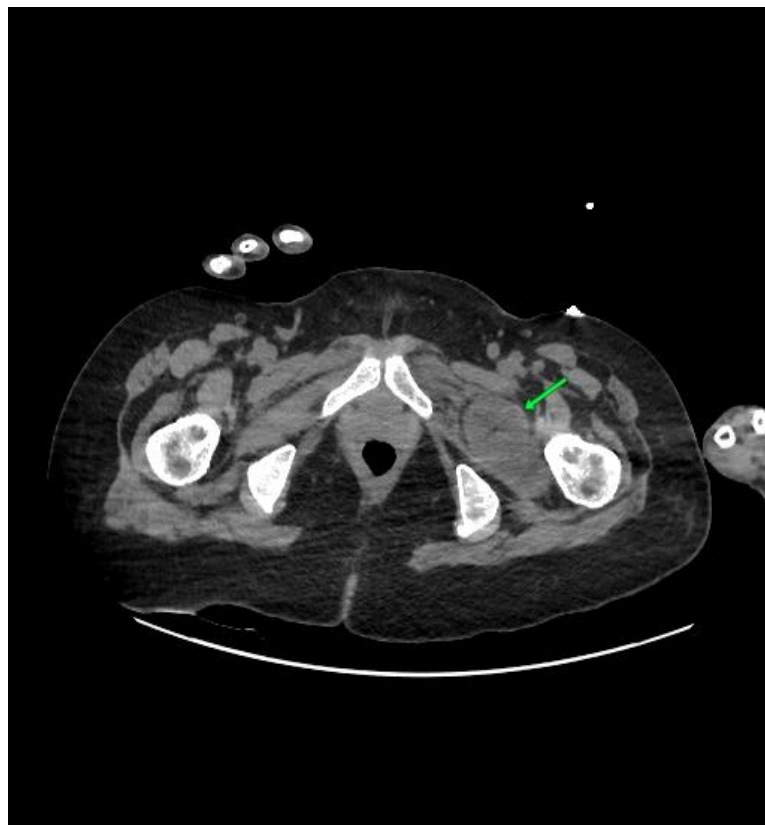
Fluid collection in LHJ area. CT axial plane.
